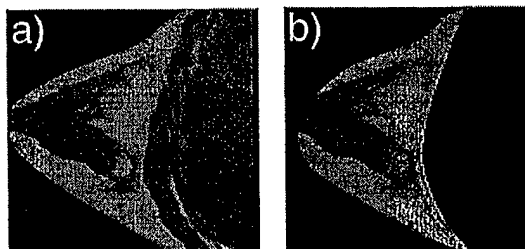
a) Precompression MR image and b) calculated post compression image of the breast.
